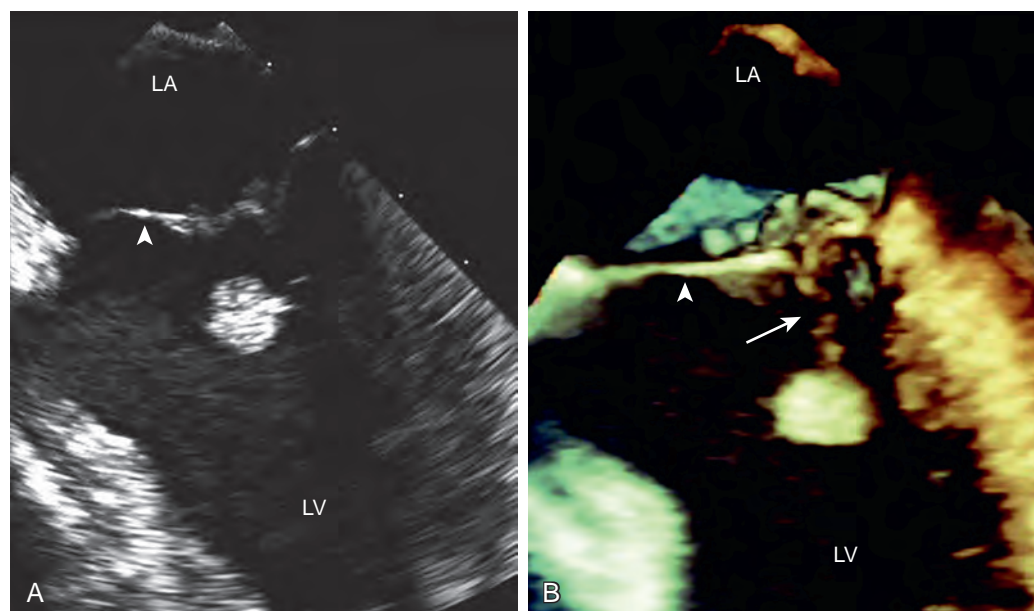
Transesophageal midesophageal two-chamber view focused on the mitral valve shows a papillary fibroelastoma attached to the ventricular surface of the mitral valve. (A) Two-dimensional and (B) three-dimensional images show the 1-cm mass attached by a stalk (arrow) to the mitral valve (arrowhead). LA, Left atrium; LV, left ventricle. (Reproduced with permission from Bruce CJ. *Cardiac tumours: diagnosis and management.* *Heart.* 2011;97:156.)
